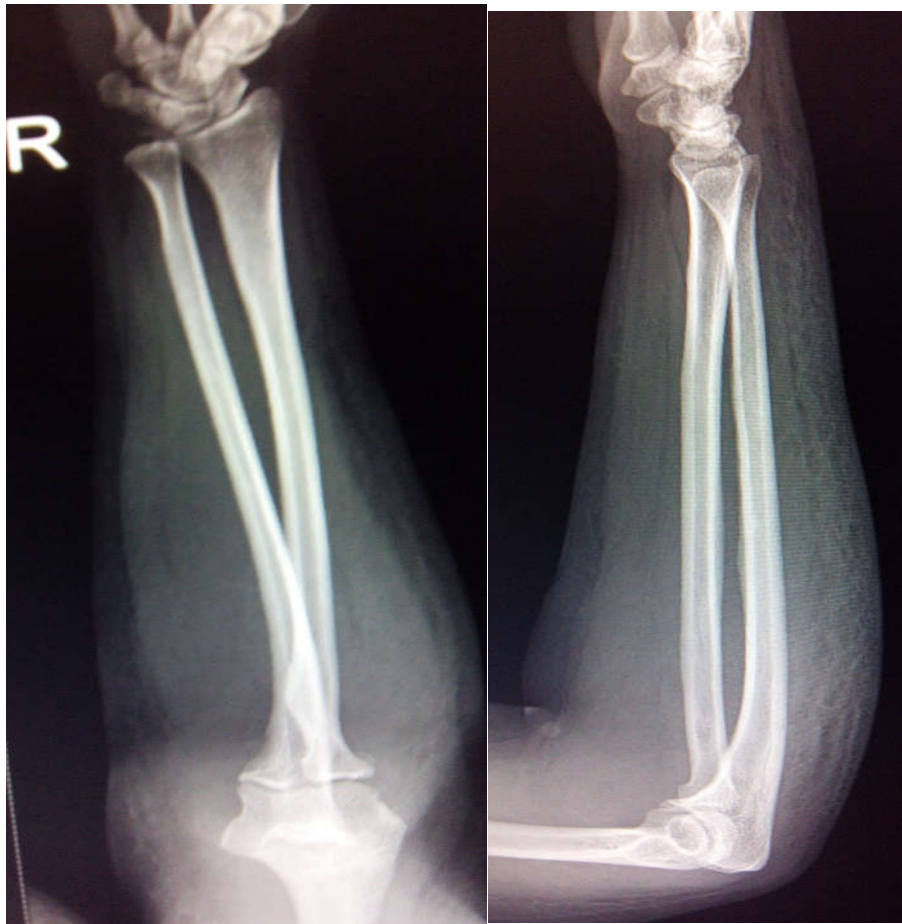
Radiograph at 3 weeks follow up with reduction maintained at superior and inferior radioulnar joints.
